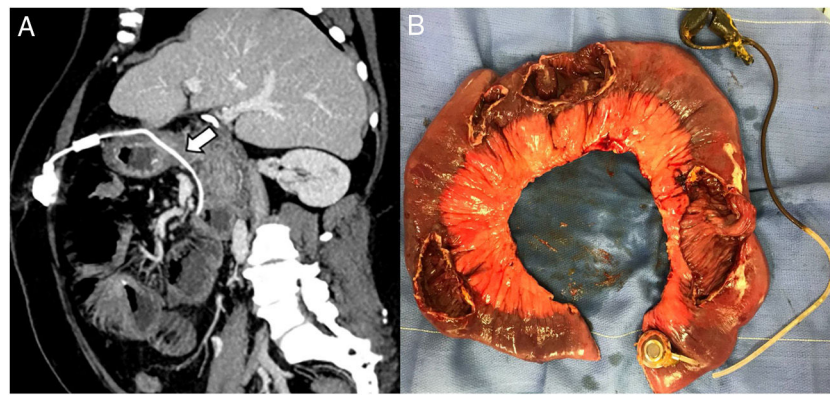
(A) CT scan of the abdomen and pelvis showing the gastric tube within the intestinal lumen (straight arrow). (B) Four long perforations at the proximal jejunum.
